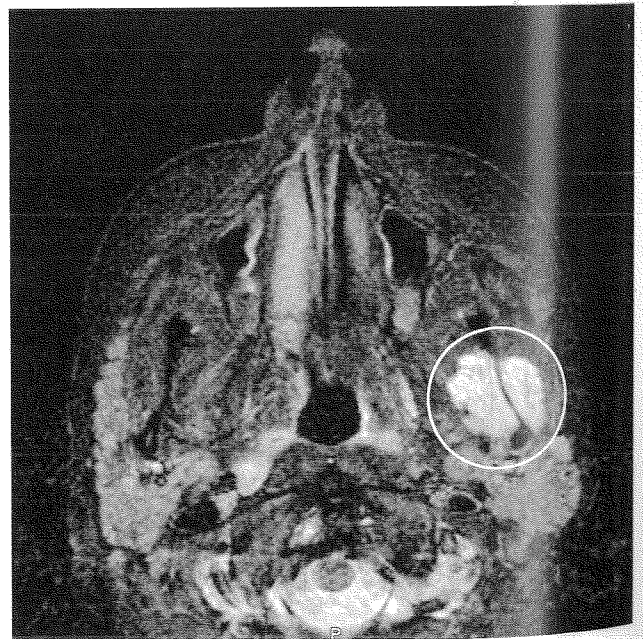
MRI imaging in case 8 shows a lobulated lesion of 2 cm medially and laterally from the mandibular notch with a high signal on the T2 weighed images and irregular contrast enhancement.
